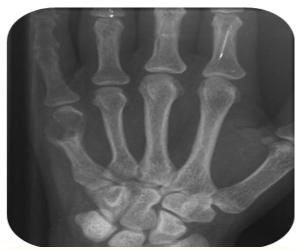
radiograph of the left hand showing brown tumor of the fifth proximal phalange
